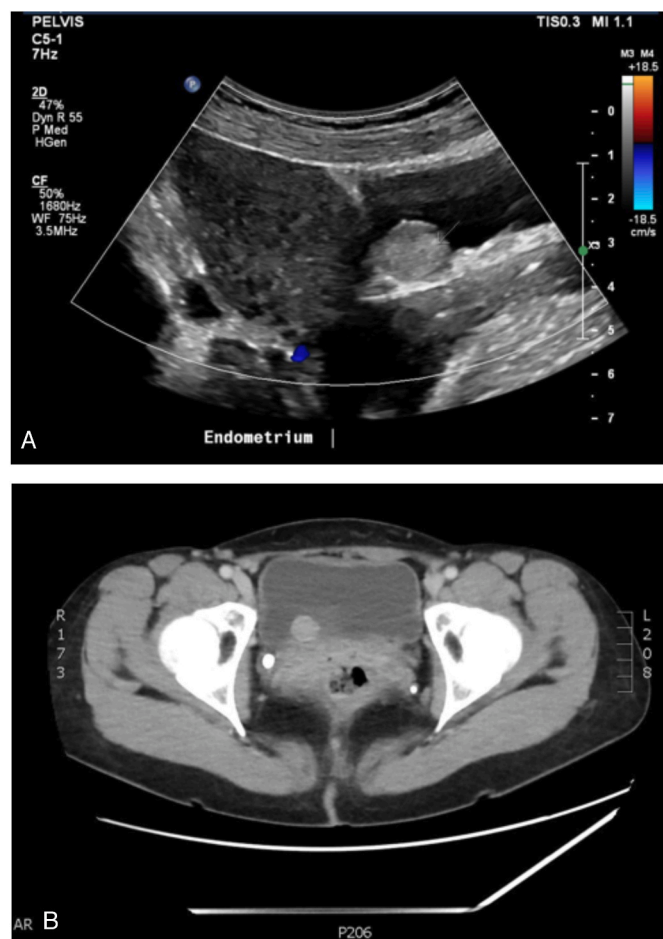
A. Ultrasound pelvis demonstrating small, well circumscribed intra-vesical bladder lesion. Fig. 1-B. Same lesion confirmed on CT imaging. Fig. 1-C. Same lesion appearance on flexible cystoscopy.
